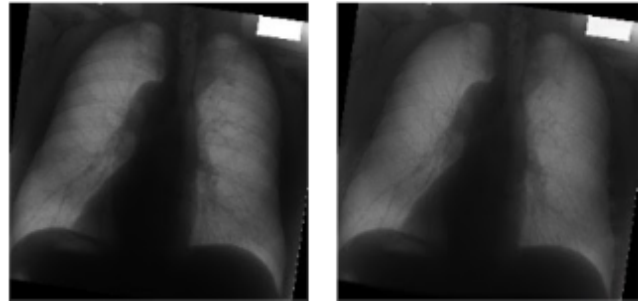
Demonstration of the result generated by our bone-suppress model: The original Chest X-ray scan (left) and the bone-suppressed version of that Chest X-ray scan (right).
